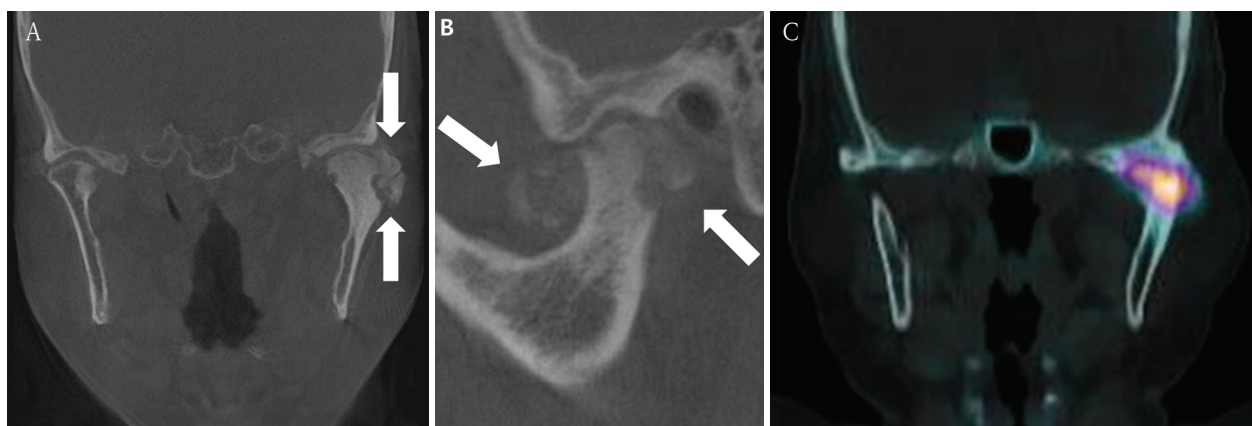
Radiographic findings of the left temporomandibular joint. A. Coronal cone-beam computed tomography (CBCT) image shows multiple calcified loose bodies (arrows) around the left condylar head. B. Sagittal CBCT image demonstrates bony erosion and sclerotic changes of the left condyle, along with multiple calcified loose bodies (arrows). C. Bone single-photon emission computed tomography/computed tomography reveals increased radiotracer uptake in the left condyle, suggesting active bone metabolism.
